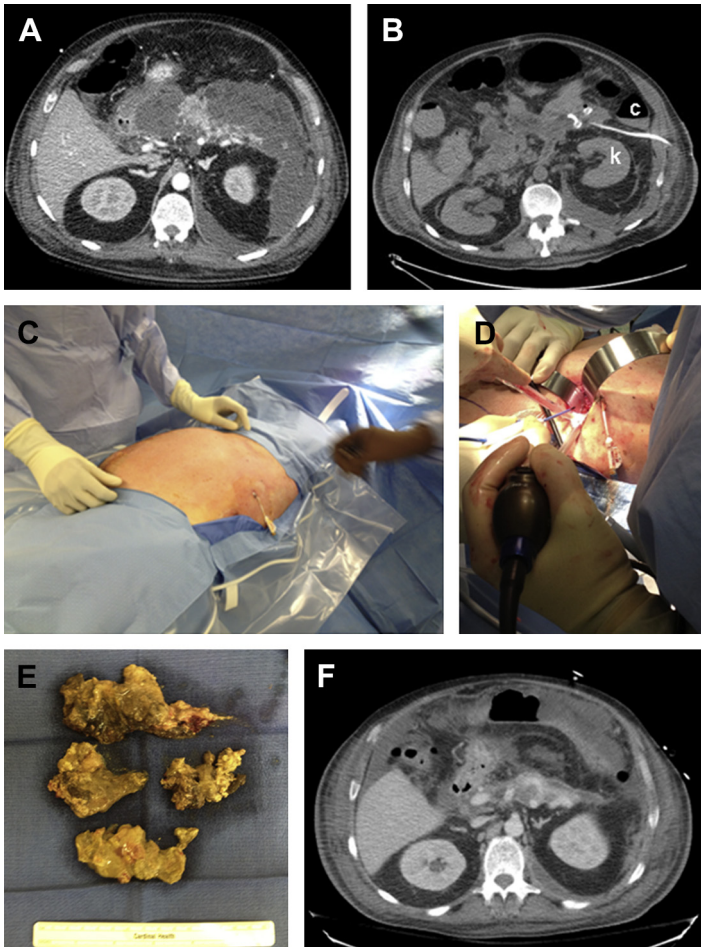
Video-assisted retroperitoneal pancreatic debridement (VARD). (A) CT scan showing walled off pancreatic necrosis amenable to retroperitoneal access. (B) Percutaneous drain placed via a retroperitoneal route to guide VARD. C, colon; K, kidney. (C) Positioning in the operating room with right side elevated and percutaneous drain prepped into the operative field. (D) Dissecting along the percutaneous drain tract into the necrosis cavity. (E) Necrotic pancreatic tissue removed by VARD. The ruler is 15 cm long. (F) Postoperative CT scan showing resolution of the necrosis cavity.
